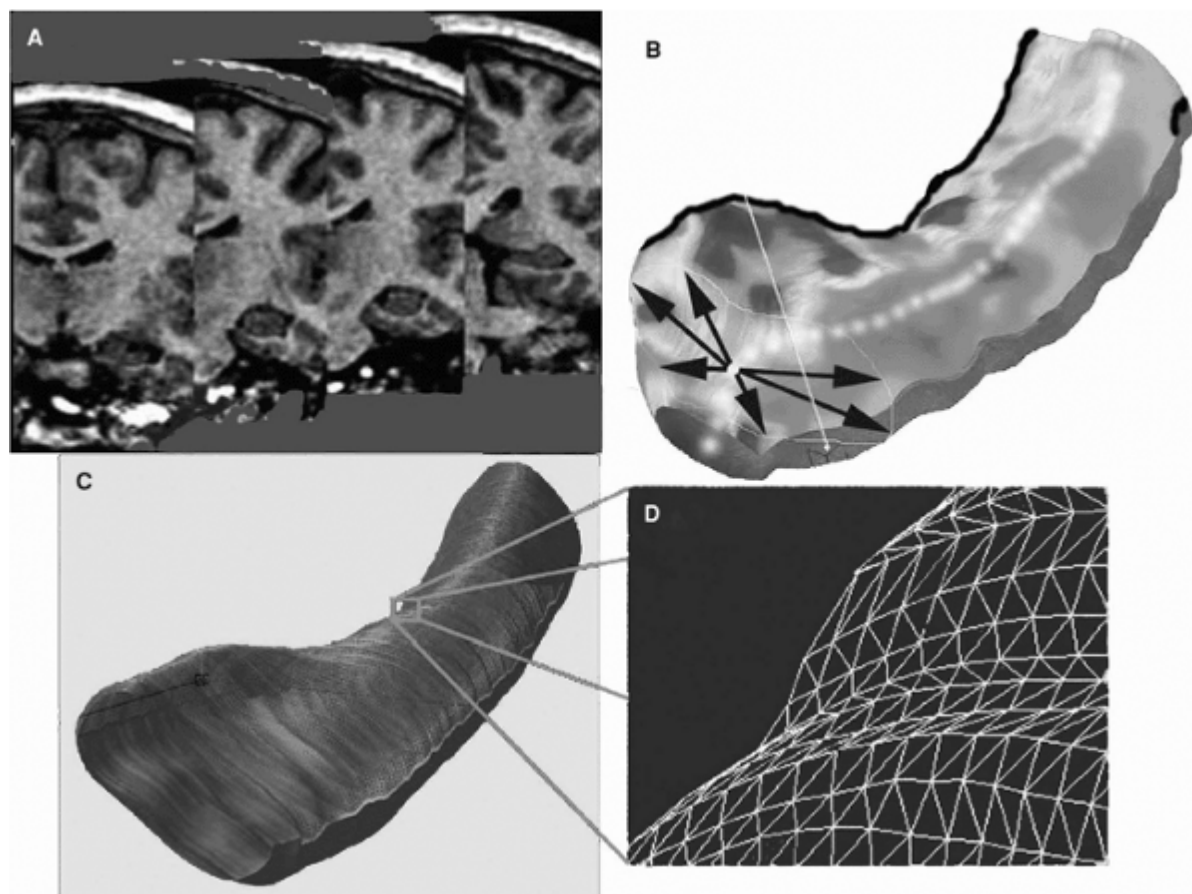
Steps involved in three-dimensional (3D) hippocampal modeling. Each individual's hippocampus is traced in consecutive coronal magnetic resonance imaging sections (A) and converted to a 3D parametric surface (B) in which the radial size of the hippocampus is measured from a centerline and plotted in color on the surface to index radial atrophy. These meshes are averaged across subjects (C), and atrophy relative to control means is computed at each surface grid point (D). (See the color insert.)
